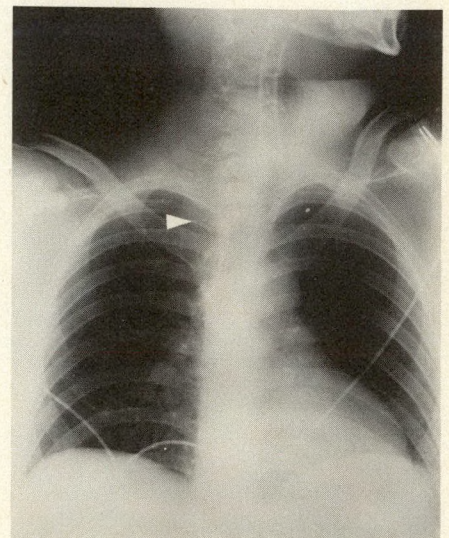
Intraoperative roentgenogram of neck and chest (Jan. 25, 1978) made during second attempt to retrieve tubing from neck. Top of cut shunt tubing (arrow) is now 2 cm cephalad to right clavicle.
